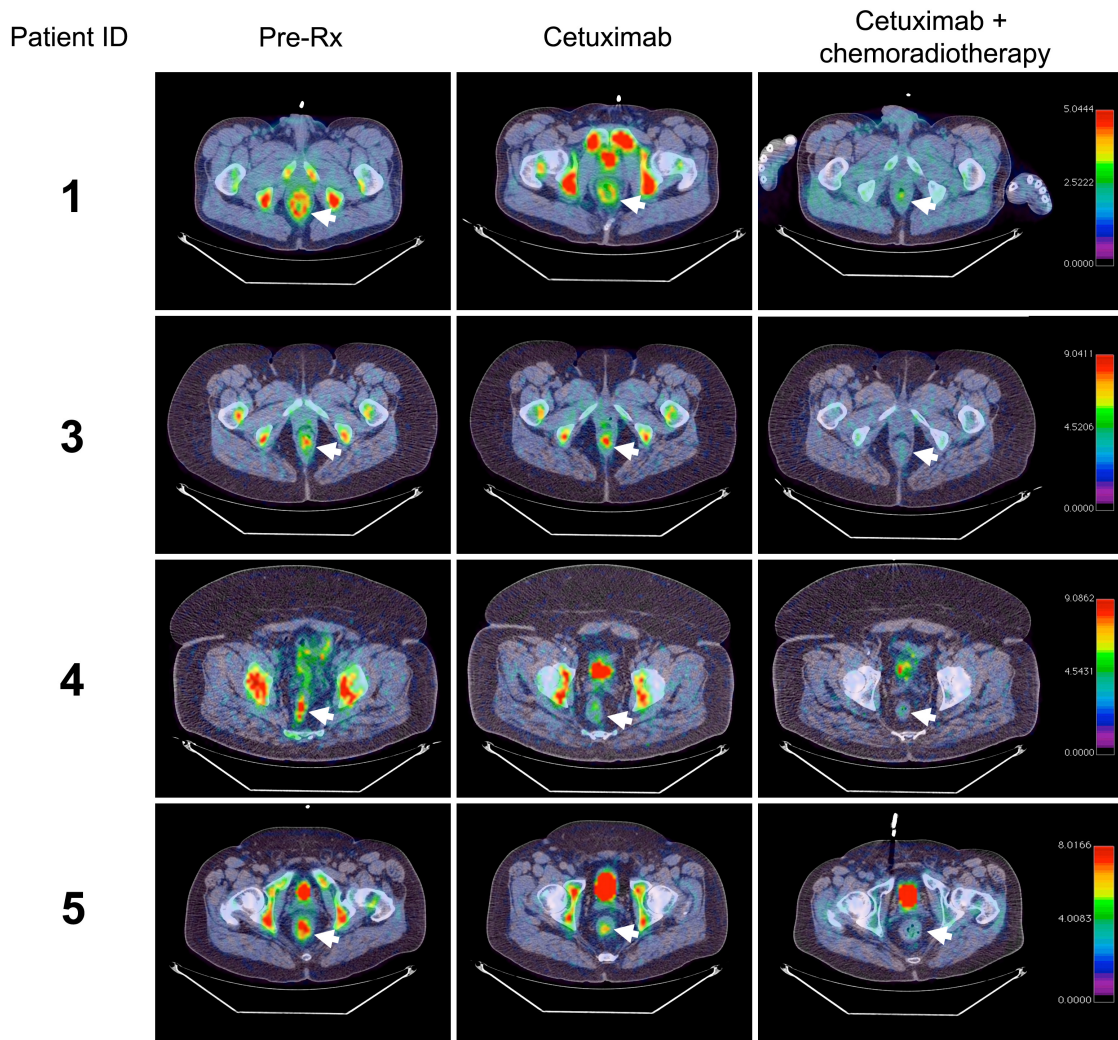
[¹⁸F]-FLT PET/CT imaging. Transverse, coregistered [¹⁸F]-FLT PET/CT images for each patient completing the study are shown at pre-treatment, post-cetuximab therapy, and after combined cetuximab-chemoradiotherapy. Tumors are denoted by arrow. Images for each patient are windowed similarly.
